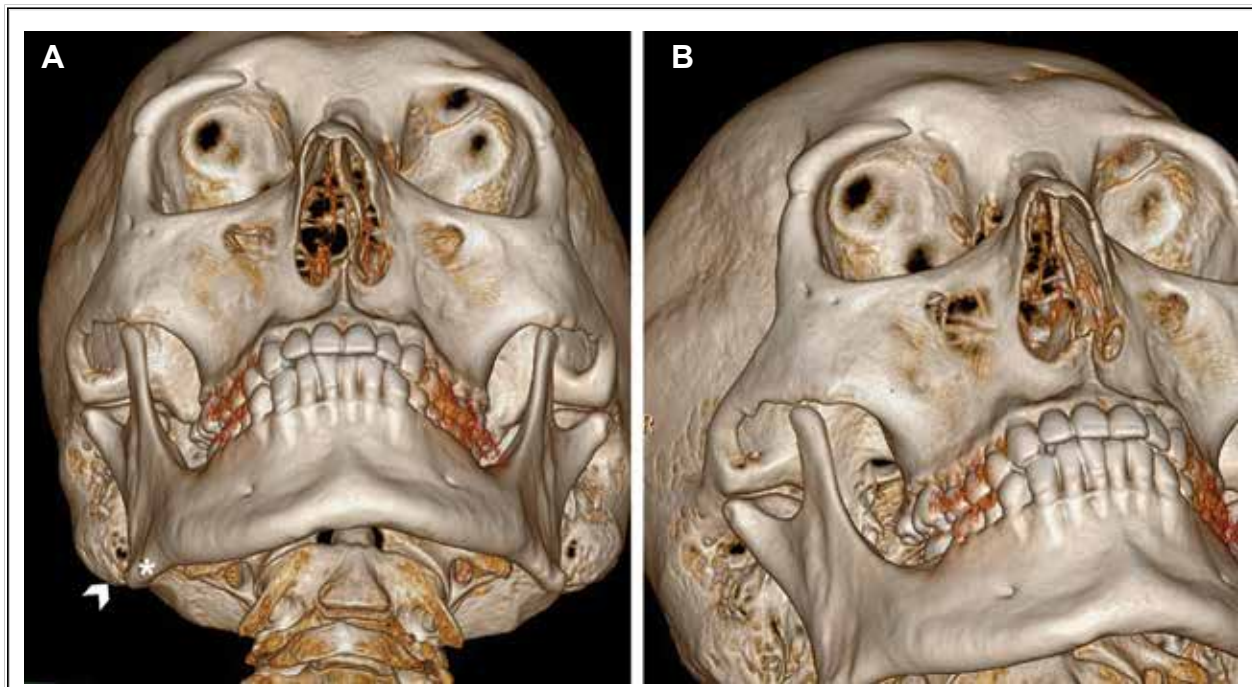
(A) 3D facial CT scan with overlap of the mandibular angle (asterisk) and the occipital cortical line (arrowhead). (B) 3D facial CT image: The mandible angle and the occipital cortex line were overlapped and turned obliquely to achieve best view of the FO.
